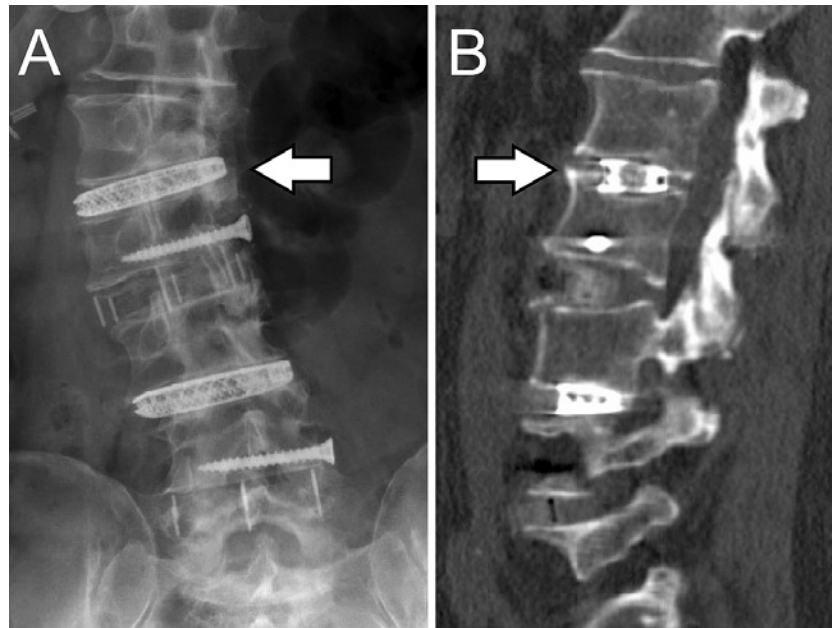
Close-up view of anterior-posterior radiograph (A) and lateral computed tomography (B) of the lumbar spine following stage 1 of a front-back thoracolumbar instrumentation demonstrating polyetheretherketone cages with lateral screw fixation following anterior column release at L2/3 and L4/5 as well as titanium cages at L1/2 and L3/4 with subsidence of the L1/2 cage (arrow) into the superior endplate of L2.
